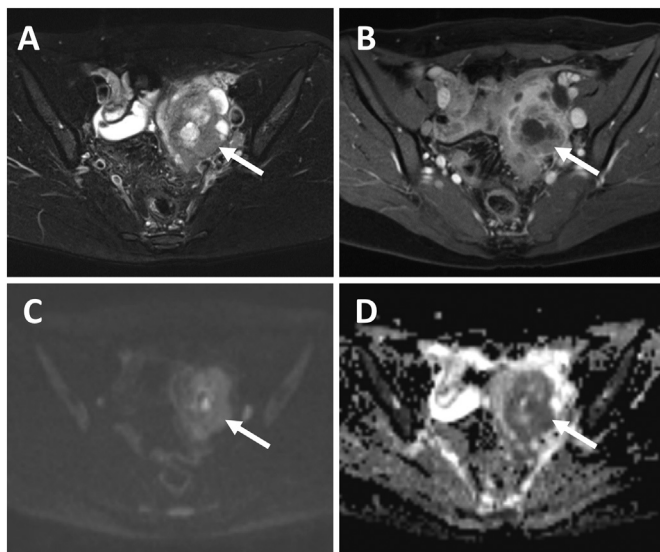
Axial sections of pelvic MRI. A and B: T2-weighted image (WI) with Fat-saturation (Fat-Sat) (A) and gadolinium-enhanced T1-WI with Fat-Sat (B). A tumor that was 6 cm in diameter (white arrow) with solid and cystic components was detected on the left side of the pelvic cavity. No fat signal was indicated in this tumor. C and D: A diffusion-weighted image (DWI) (C) and apparent diffusion coefficient (ADC) map (D). The tumor (white arrow) showed reduced diffusion (high intensity of DWI) and low ADC, suggesting malignancy.
